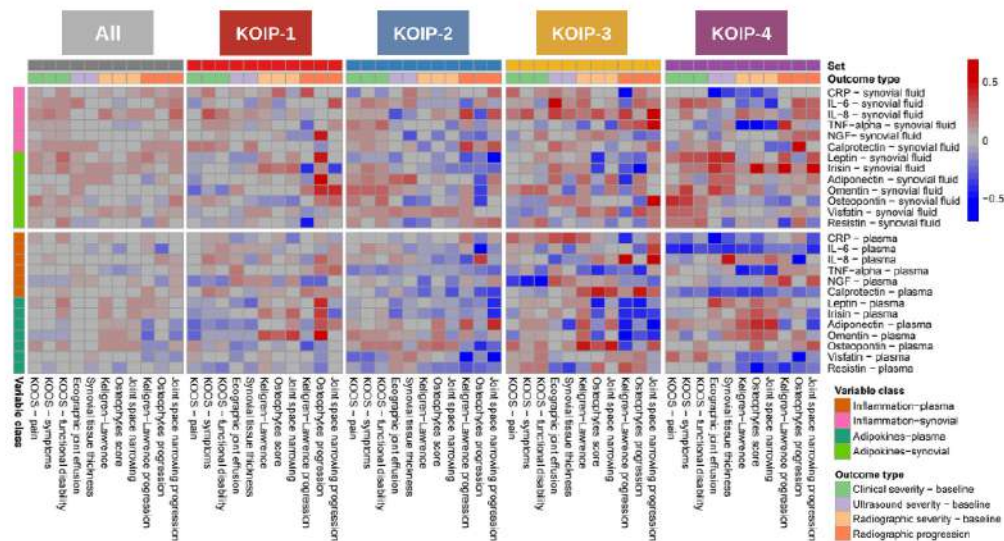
Association of cytokines with knee osteoarthritis (KOA) severity and progression stratified by KOA inflammatory phenotypes (KOIP). The heatmap colours represent non-parametric correlation-like measurements to assess the association of the cytokines evaluated in our study with KOA outcomes, including clinical, radiographic and ultrasound severity at baseline, and radiographic progression at 2 years. Associations were assessed for the overall series and within each KOIP independently using Spearman correlations (continuous or ordinal outcomes) and Glass rank biserial correlations (binary outcomes). Baseline Kellgren-Lawrence staging and joint space narrowing were treated as ordinal in these analyses. Red indicates positive, blue represents negative, and colour intensity expresses more extreme values of the correlation coefficients. Colour intensities were saturated to 0.5 and -0.5 for positive and negative correlation, respectively. IL-6, interleukin 6; IL-8, interleukin 8; TNF- α , tumour necrosis factor alpha; NGF, nerve growth factor; CRP, C-reactive protein; KOOS, Knee injury and Osteoarthritis Outcome Scores (reversed scores); KOA, knee osteoarthritis; KOIP, knee osteoarthritis inflammatory phenotype
